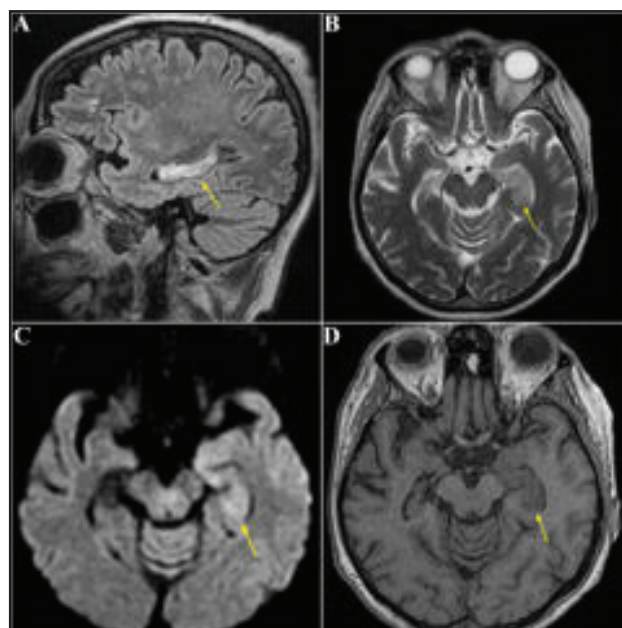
Brain MRI: Three weeks after first brain MRI, there is a decrease in the hyperintensity on FLAIR (A) and T2 weighted (B) imaging in the left medial temporal lobe; DWI shows slight reduction in intensity (C) as does the T1 imaging (D).
